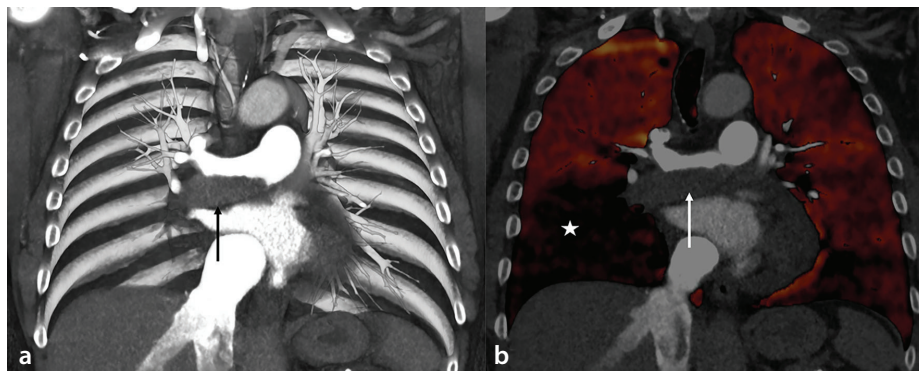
(a) Coronal computed tomography pulmonary angiography shows eccentric thrombus in the right main pulmonary artery (black arrow) and occlusion of the right lower lobe vessels. (b) Dual-energy iodine map demonstrates a corresponding lobar perfusion defect in the right lung (star). Perfusion is also abnormal in the left lung due to subsegmental thrombi.
